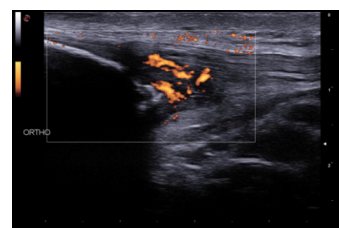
Power Doppler technology - orthostatic conditions.
